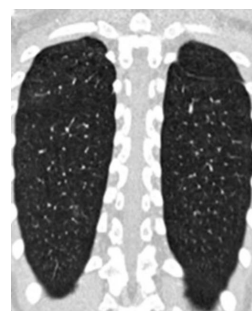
After 4 weeks of treatment, repetition of chest CT scan showed resolution of pulmonary localisations.
